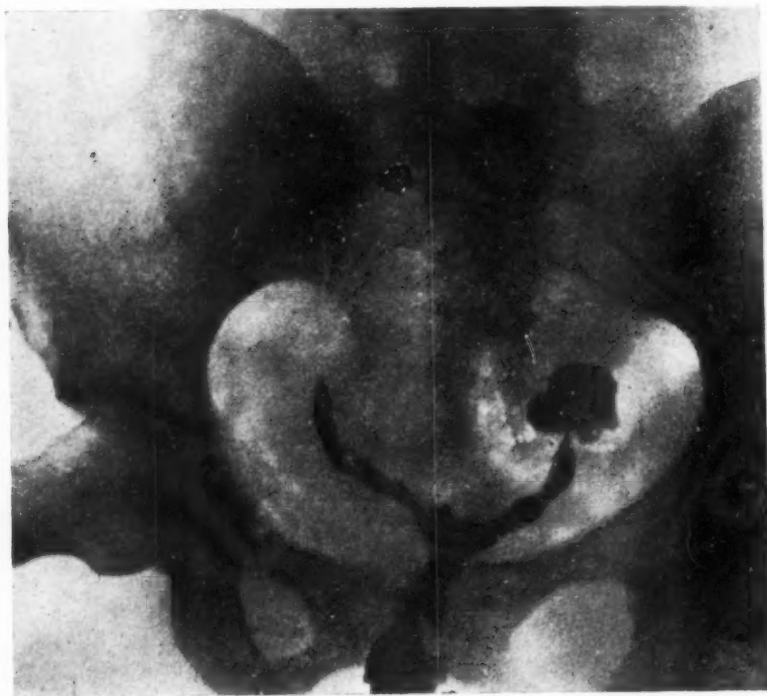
X-ray picture of injected uterus.
